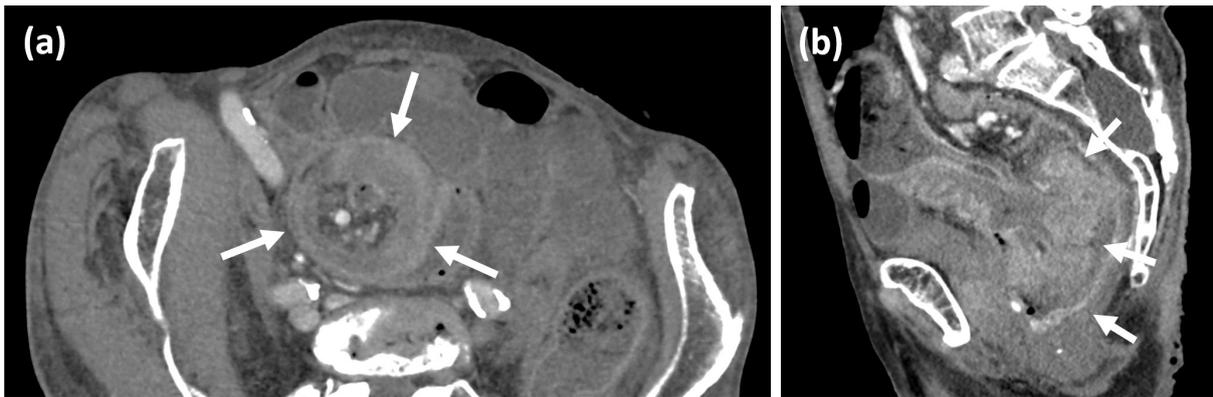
Contrast-enhanced CT scan of the pelvis, transverse section (a) and sagittal section (b). The intussusception is depicted as telescoping of the sigmoid colon and its mesosigmoid into the rectum with typical 'target-sign' as seen in image (a) and large ill-defined mass within the rectal lumen (white arrows).
